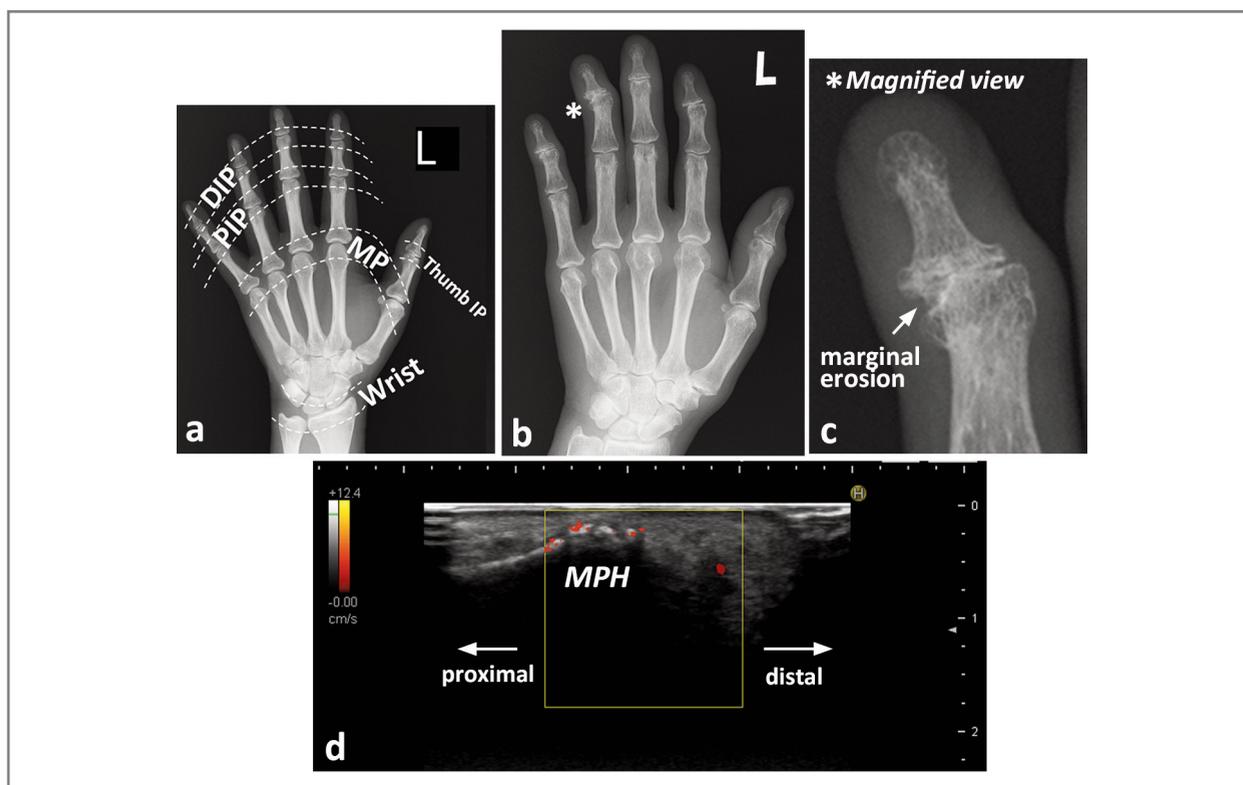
a, In this study, bone erosions are evaluated in the DIP joint, PIP joint, IP joint, MP joint, and wrist. b and c, A 62-year-old woman with a 12-year history of RA. The DAS28-CRP is 2.2, which indicates that activity of RA is well controlled. However, marginal bone erosion of the DIP joint deformity is observed at the fourth finger on the left side on the anteroposterior hand radiograph (asterisk and arrow). d, The findings of ultrasound for the DIP joint in the fourth finger on the left side. Bone erosions and slight tenosynovitis are observed at the middle phalanx head (MPH).
